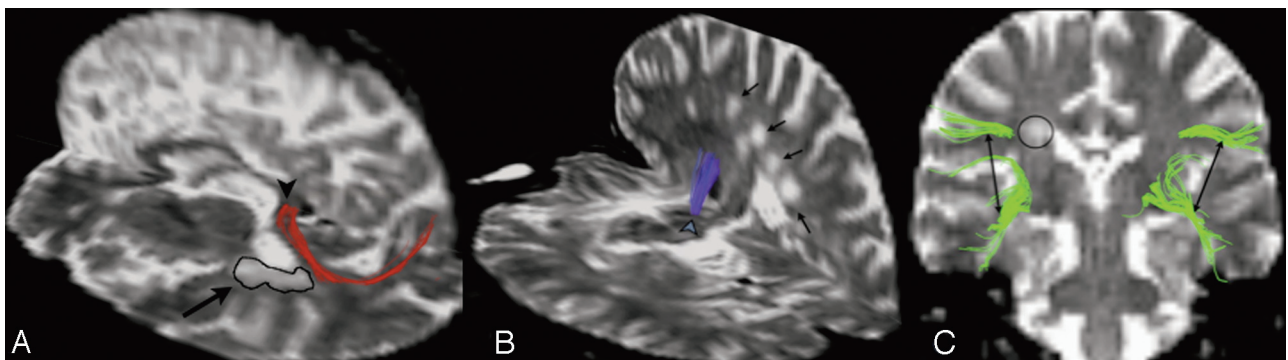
Callosal, projection, and association fibers passing through NAWM. *A*, Callosal fibers from the splenium of the CC passing through NAWM on the background of axial and sagittal planes of $b = 0$ T2-weighted images. A black arrow points to the T2 lesion on the axial plane, and the arrowhead points to the fibers from the splenium of the CC passing through NAWM. *B*, Projection fibers pass through NAWM in the background of the axial and sagittal planes of $b = 0$ T2-weighted images. Black arrows point to the T2 lesions, and the arrowhead points to the projection fibers passing through NAWM. *C*, The T2 lesion is circled, and the arrows point to the association fibers passing through NAWM.
